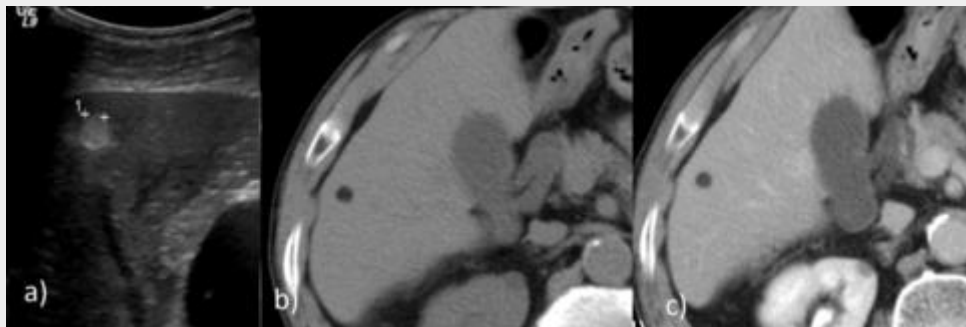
Patient with a small hepatic lipoma. In ultrasound there is a hyper echogenic small lesion (a), that has a very low attenuation in CT study equal to subcutaneous fat (b), no enhancement was found after contrast injection (c).
